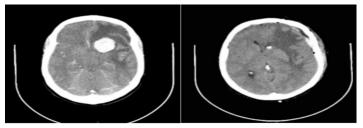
Axial section CT, Preoperative examination - one day before surgery and postoperative examination - first day after surgery.
